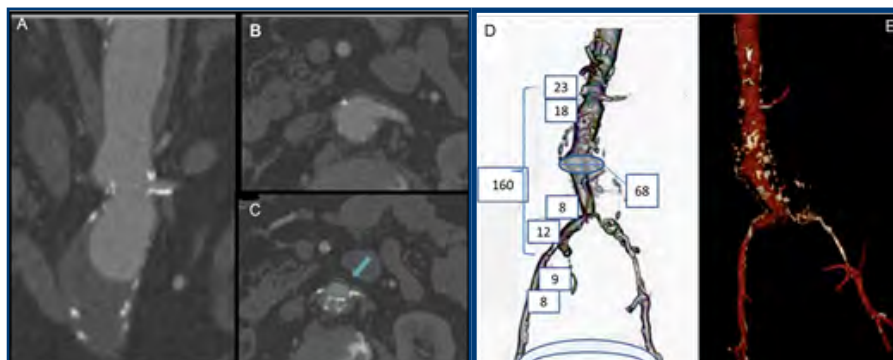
Preoperative coronary computed tomography angiography. Juxtarenal aneurysm (sagittal projection) without infrarenal neck. 1-B. Left renal artery. 1-C. Presence of a 9 mm infrarenal stenotic annular calcification (arrow). 1-D. Surgical plan. Measures in mm. Presence of a 68 mm maximum aortic diameter. Segment to be covered of 160 mm. 23 mm aortic diameter at superior mesenteric artery (SMA) level. Proximal anchorage neck at inferior mesenteric artery (IMA) level of 18 mm in length. Presence of an 8 mm stenosis at right common iliac artery (CIA) level. Femorofemoral crossing bypass surgery for PTFE graft implantation. 1-E. 3D reconstruction of the case.
